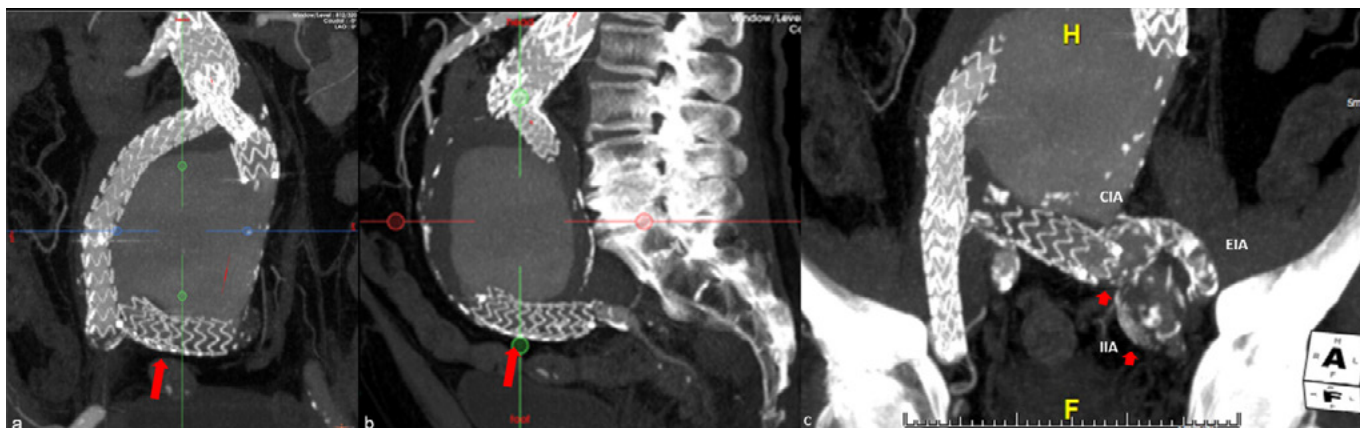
(a,b). Pre-op CT scan demonstrating the IIIa endoleak. The disconnected left limb of the endograft is within the sac of the aneurysm. 1c. Left CIA and IIA aneurysms. Loss of distal fixation of the left limb of the endograft. CIA: Common Iliac Artery, EIA: External Iliac Artery, IIA: Internal Iliac Artery
